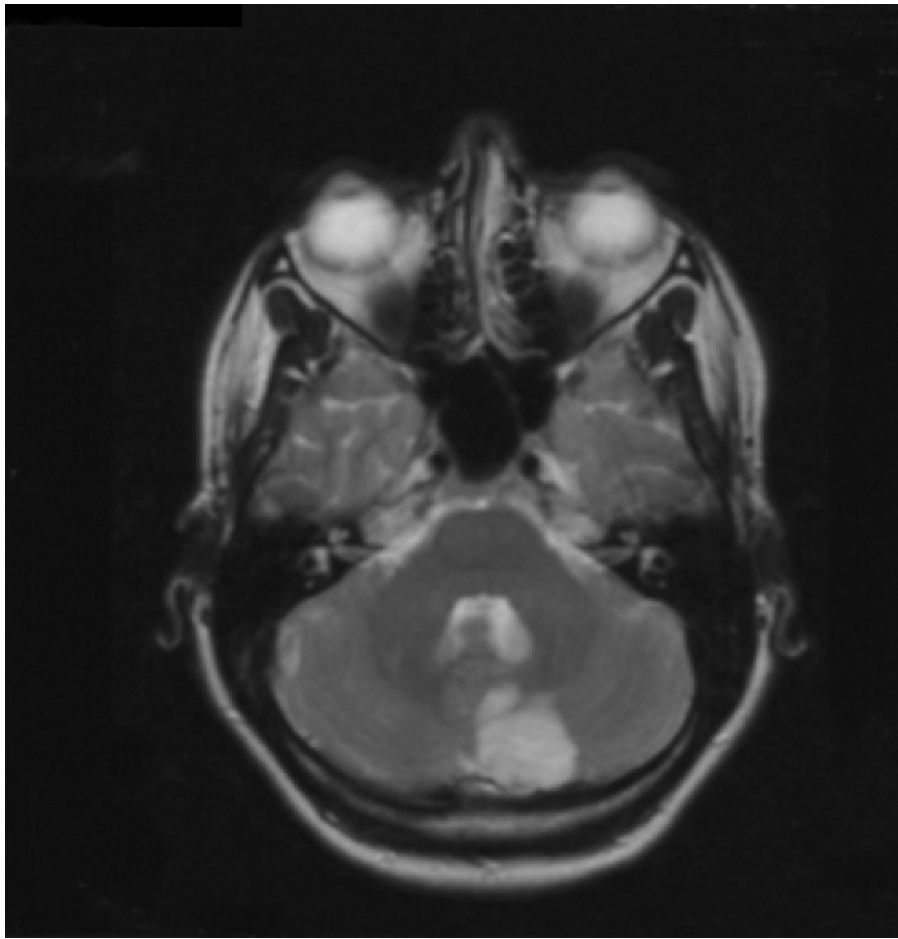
Magnetic resonance imaging brain scan showing a large left cerebellar infarct.
